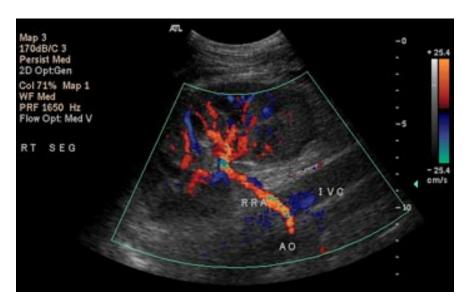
Color flow doppler of kidney and renal artery. RRA, right renal artery; AO, aorta; IVC, inferior vena cava; © 2016 UC Regents.
